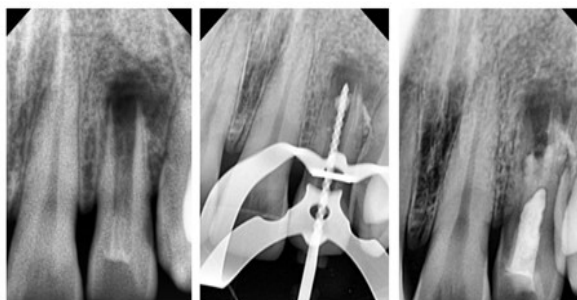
(a) Pre-op radiograph (b) Working length determination (c) Biodentine lining
